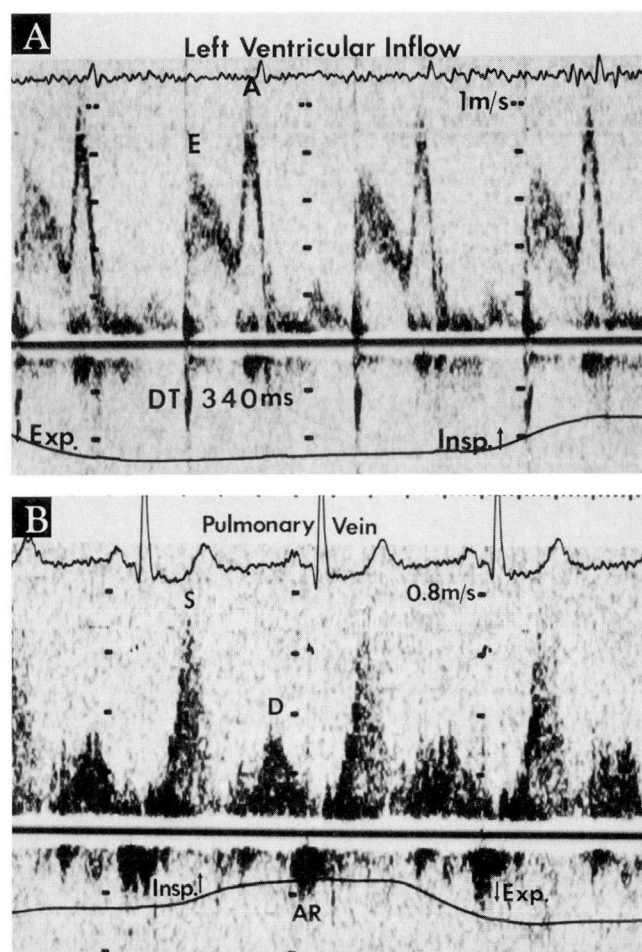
Abnormal relaxation flow pattern of left ventricular inflow in early cardiac amyloidosis. A. Pulsed-wave Doppler recording of a left ventricular inflow profile with decreased peak E velocity and increased peak A velocity. The E/A ratio was decreased (0.6) and deceleration time (DT) was prolonged (340 ms). B. Pulsed-wave Doppler recording of right upper pulmonary vein flow profile with increased peak forward systolic (S) and decreased diastolic (D) flow velocities and normal reversal of atrial filling (AR). (Exp., expiration; Insp., inspiration.)
